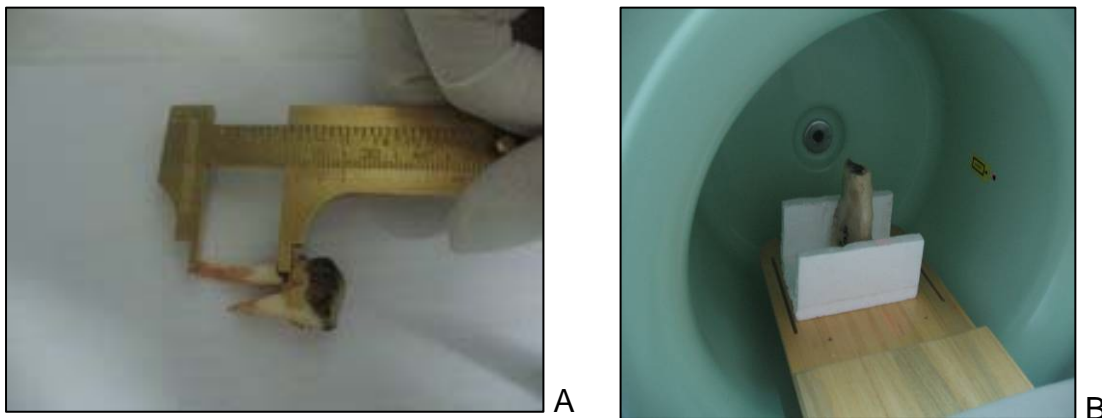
(A) root measurement after tooth extraction; (B) CBCT scanning after creating periapical bone defects and repositioning the teeth
